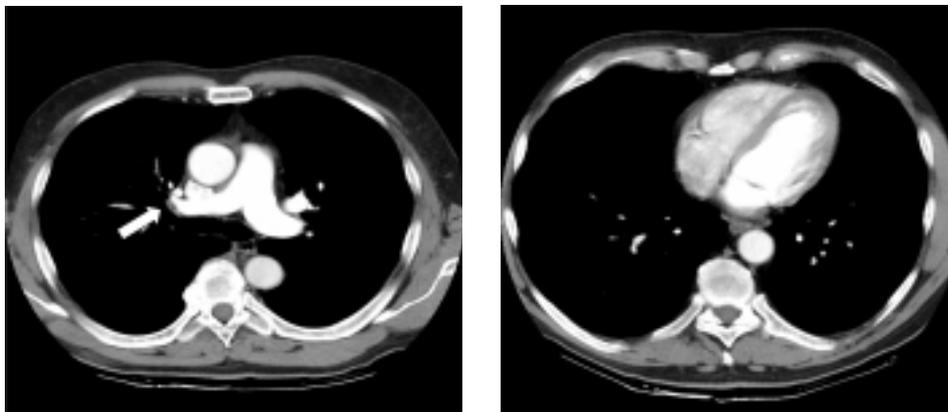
Three months after anticoagulation therapy, multislice computed tomography showed almost complete resolution of the pulmonary artery thrombosis (a thin layer of thrombus in the mid segment of the left pulmonary artery is still present, arrow) and normalization of the right ventricular dimensions.
